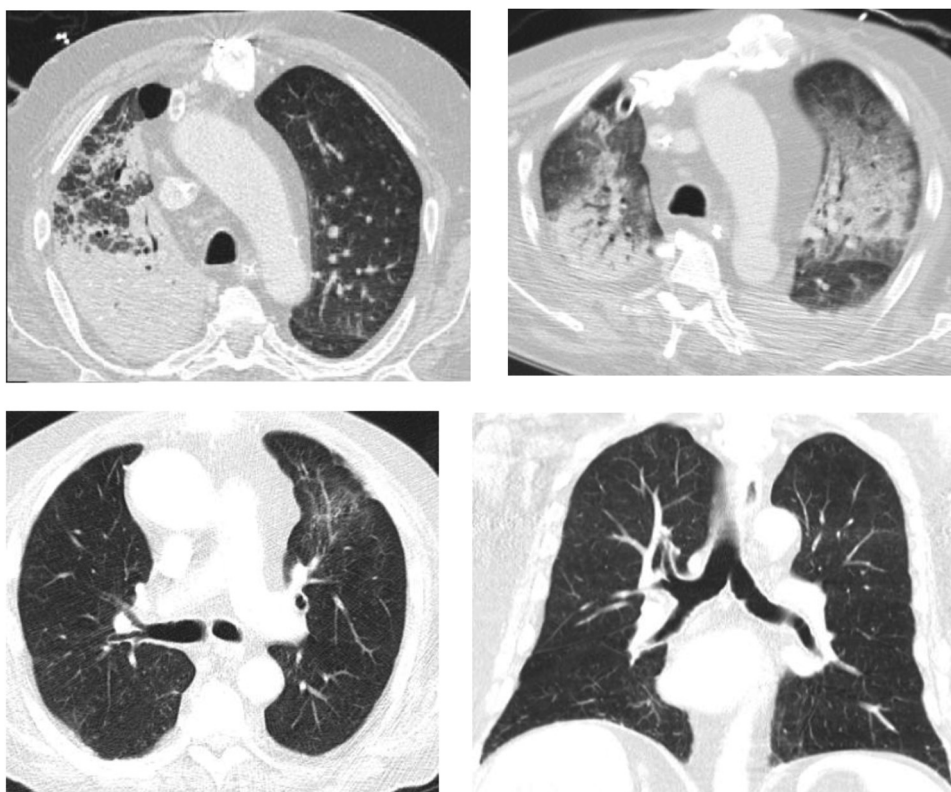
Chest CT scan on day 8 (upper left), day 23 (upper right), and on hospital discharge (lower left and right).
